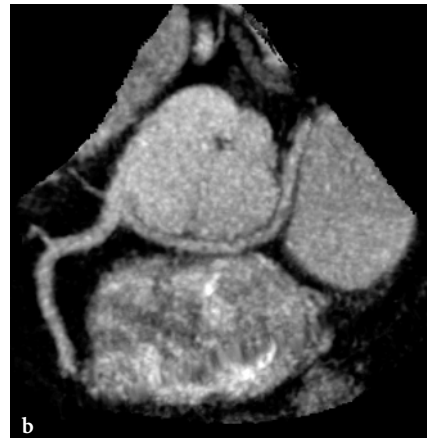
16-slice CT examination of an abnormal origin of the CX from the right sinus of Valsalva, retro-aortic course. Displayed with volume rendering (a)
